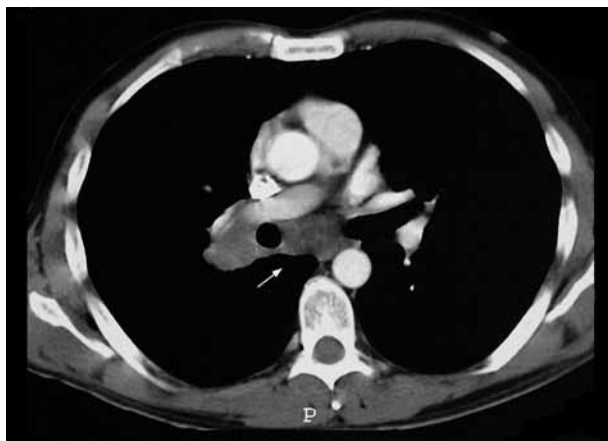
Thoracic computed tomography with mediastinal involvement in the subcarinal area of a bronchogenic carcinoma.
